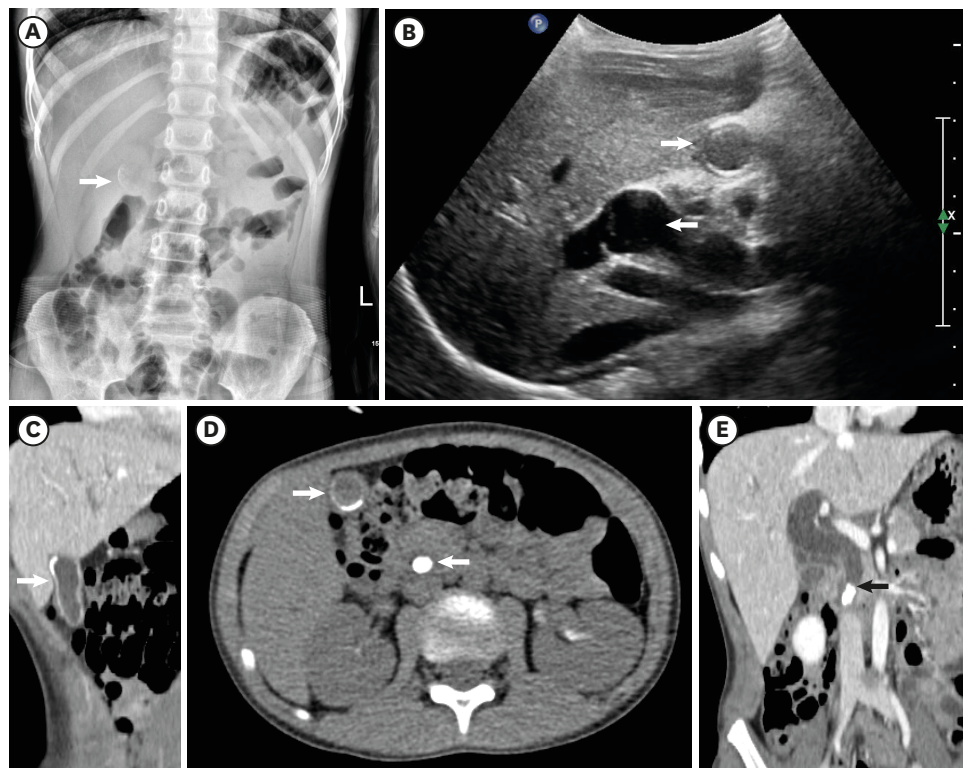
Initial simple X-ray, sonography, and abdominal CT images. (A) Erect view of posterior to anterior abdominal radiograph shows the circular, thin opacity like cyst in the right upper quadrant. (B) Liver ultrasonography shows increased homogeneous echogenicity along the intramural layer of gallbladder body (rightward arrow) and dilatation of biliary duct (leftward arrow). (C) Coronal view of CT scan shows mucosal high attenuation which is diffuse and homogeneous thin wall along the gallbladder fundus and body. (D) Calcified gallbladder wall (rightward arrow) and calcified radiopaque stone (leftward arrow) were revealed on transverse view of pre-enhanced CT scan. (E) Another coronal view of abdominal CT scan shows the stone (arrow) which is a cause of common biliary ductal dilatation. CT = computed tomography.
